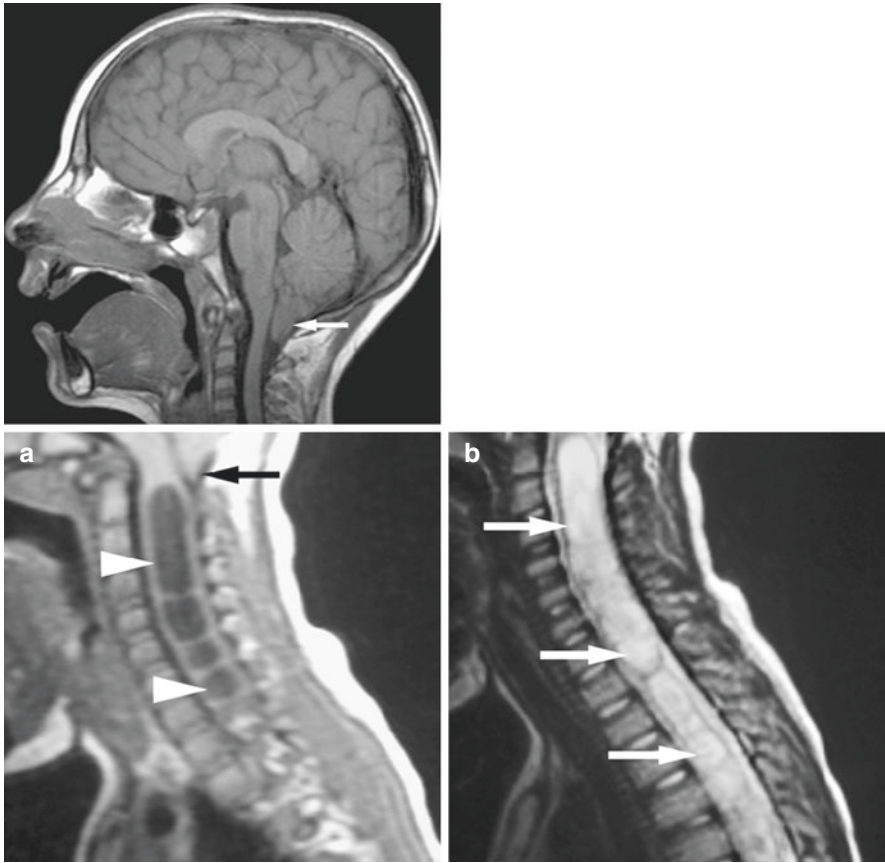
(I) Chiari malformation type I: 7-year-old female with Noonan syndrome presents with neck pain. Mid-sagittal T1-weighted MRI shows descent of point of tonsils through foramen magnum (*arrow*) and absence of CSF in cisterna magna. (II) Chiari malformation Type I; 5-year-old asymptomatic male. (a) Mid-sagittal T1-weighted MRI demonstrates caudal displacement of cerebellar tonsils (*arrow*). Dark signal in center of cervical cord represents syringo- or hydromyelia with multiple locations (*arrowheads*). (b) Sagittal T2-weighted MRI reveals associated hydromyelia with multiple locations of fluid in center of cord. These are sequelae of decreased CSF dynamics through foramen magnum (*arrows*)
